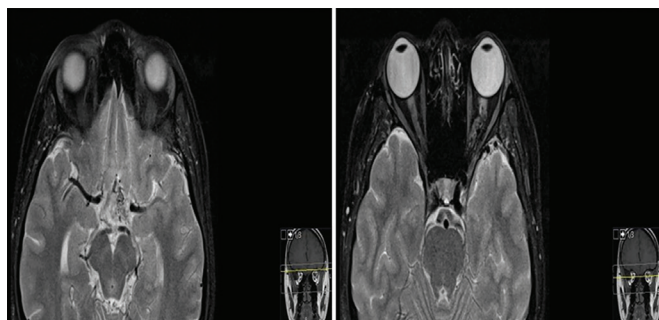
Axial T2-weighted orbital MRI images demonstrating vascular malformation along the left optic nerve, consistent with Wyburn-Mason syndrome MRI; Magnetic resonance imaging
